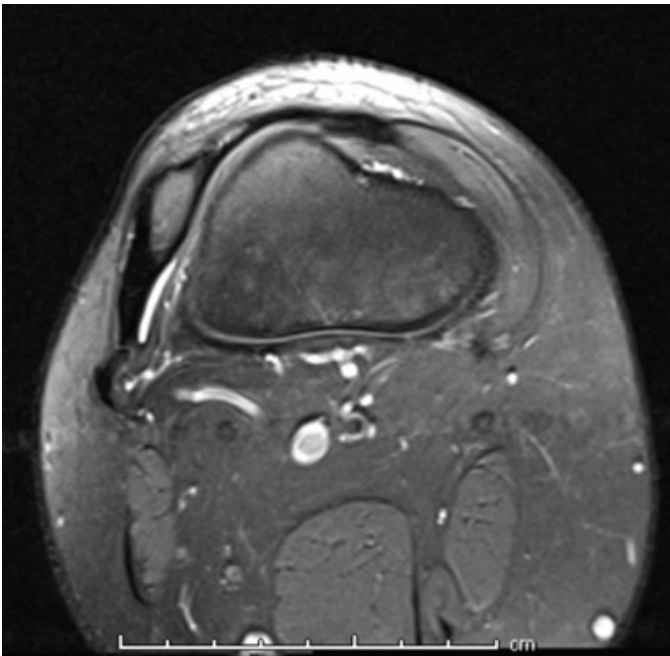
Axial T2 MRI of the right knee in a patient with a hypoplastic and fixed laterally displaced patella. Note the attenuated medial retinaculum and the thickened lateral retinaculum.
